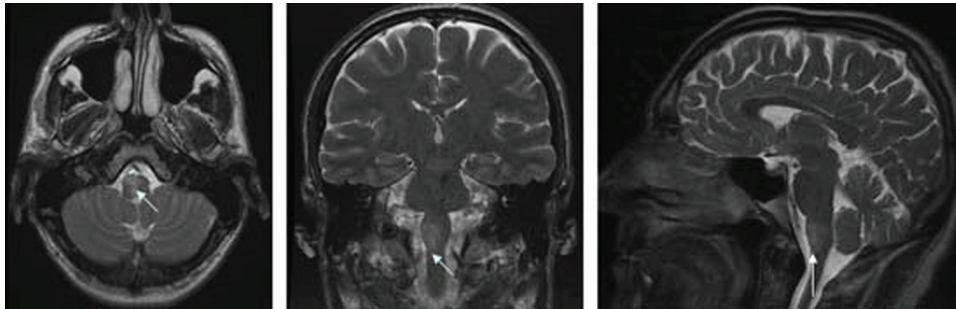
MRI – T2 axial, coronal and sagittal views; arrows – demonstrate the extent of the brain stem infarction.
